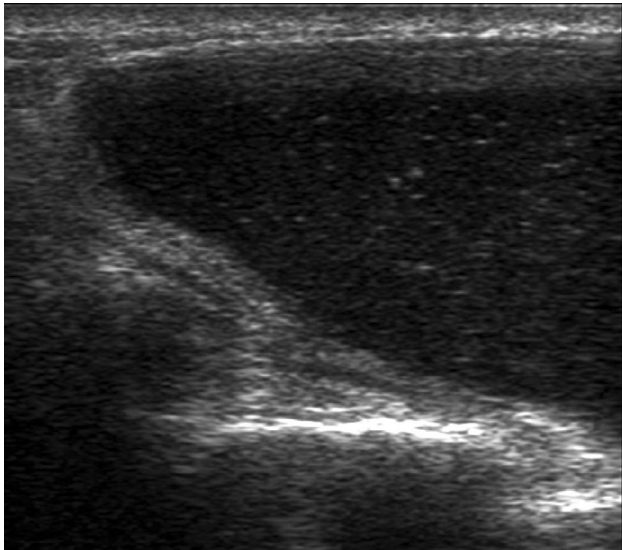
Ultrasonography image of the left gluteal swelling showing cystic lesion with internal echoes within surrounded by thin wall.
